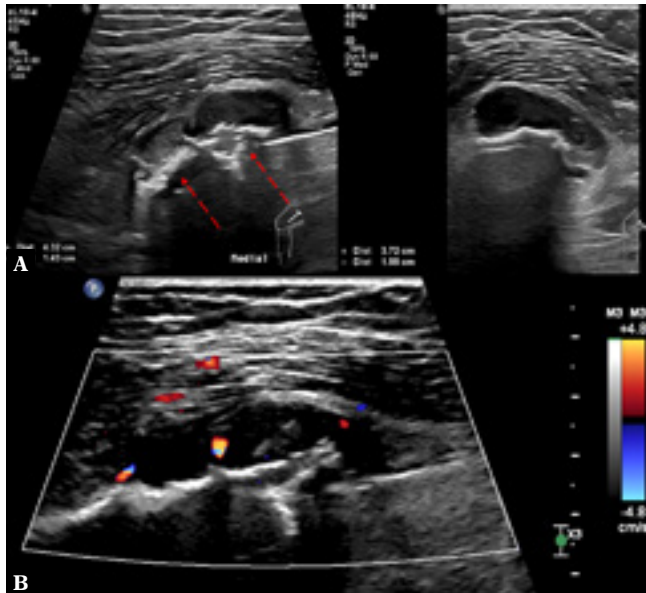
Ultrasound performed 4 years after the completion of treatment (6 months after the previous examination). Progression of the lesion size and destruction of the cortical bone (dashed arrows) not visible 6 months earlier (A); vascularization of the lesion in the color Doppler US (B)
